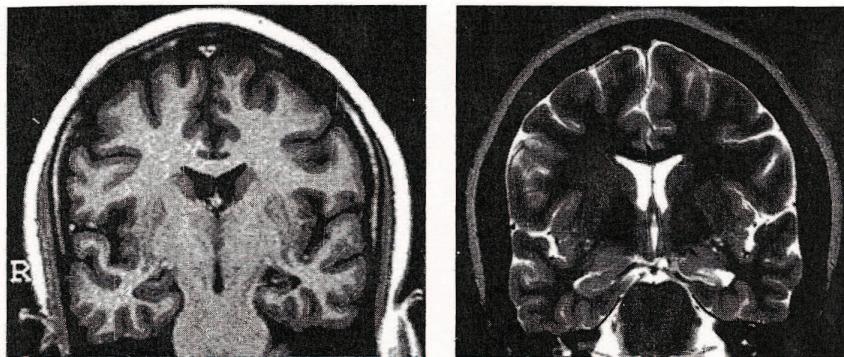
T1-weighted inversion recovery and T2-weighted coronal MRI from a patient with left HS who underwent selective amygdalohippocampectomy and became seizure-free. Observe the atrophy, loss of internal structure, hypointense signal on T1-weighted, and hyperintense signal on T2-weighted image.
